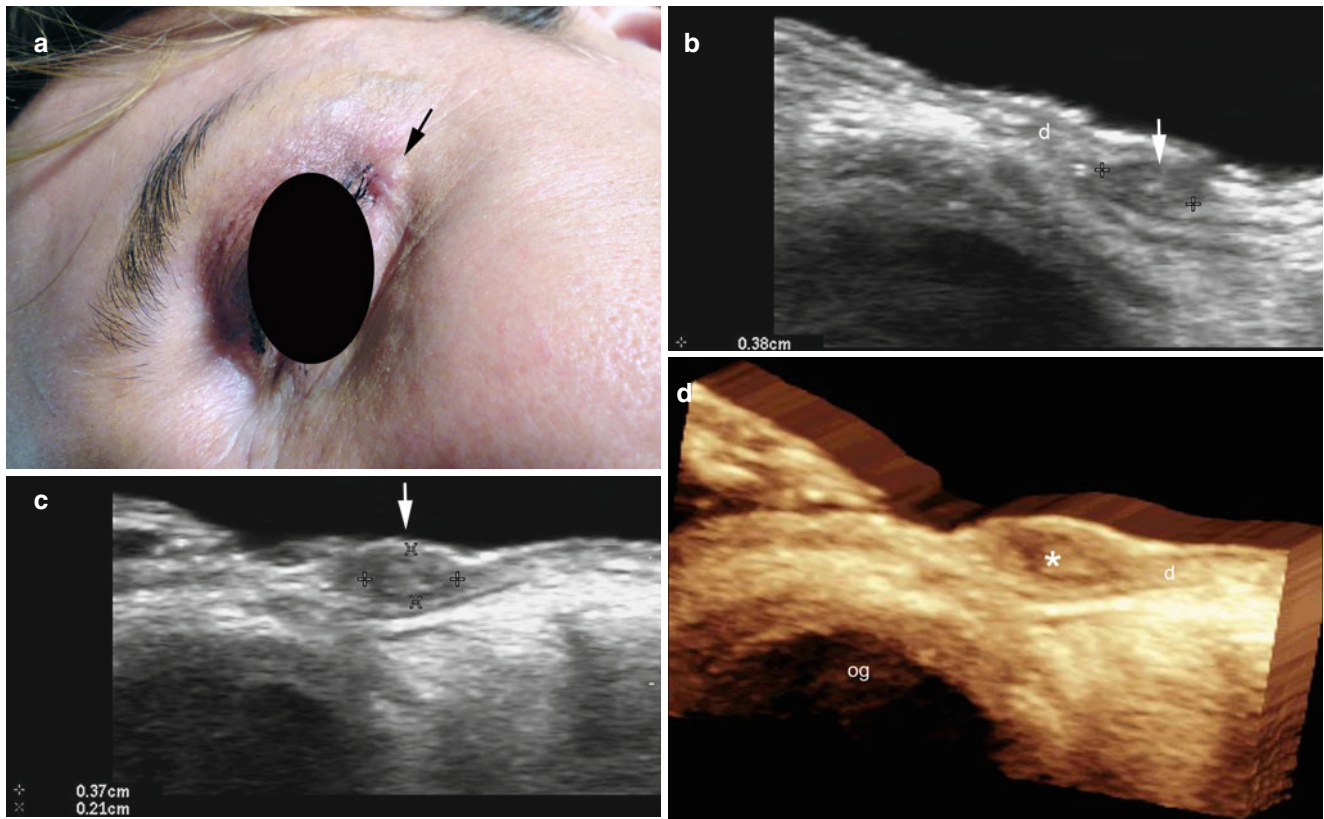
(a–d) Granuloma after blepharoplasty. (a) Clinical image demonstrates a erythematous lump (*arrow*) in the external canthus of the left eye. (b–d) Grey scale ultrasound images (b longitudinal view; c transverse view and d 3D reconstruction longitudinal view) show a
